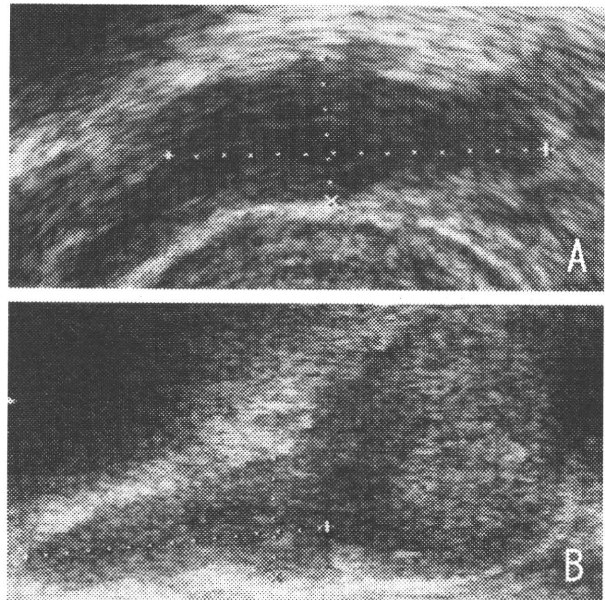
Demonstration of measurement of seminal vesicle with transrectal ultrasonography. (A) Transverse view (measurement of anterior-posterior diameter, dotted line from top to below). (B) Longitudinal view (measurement of lateral diameter, dotted line from left to right).
